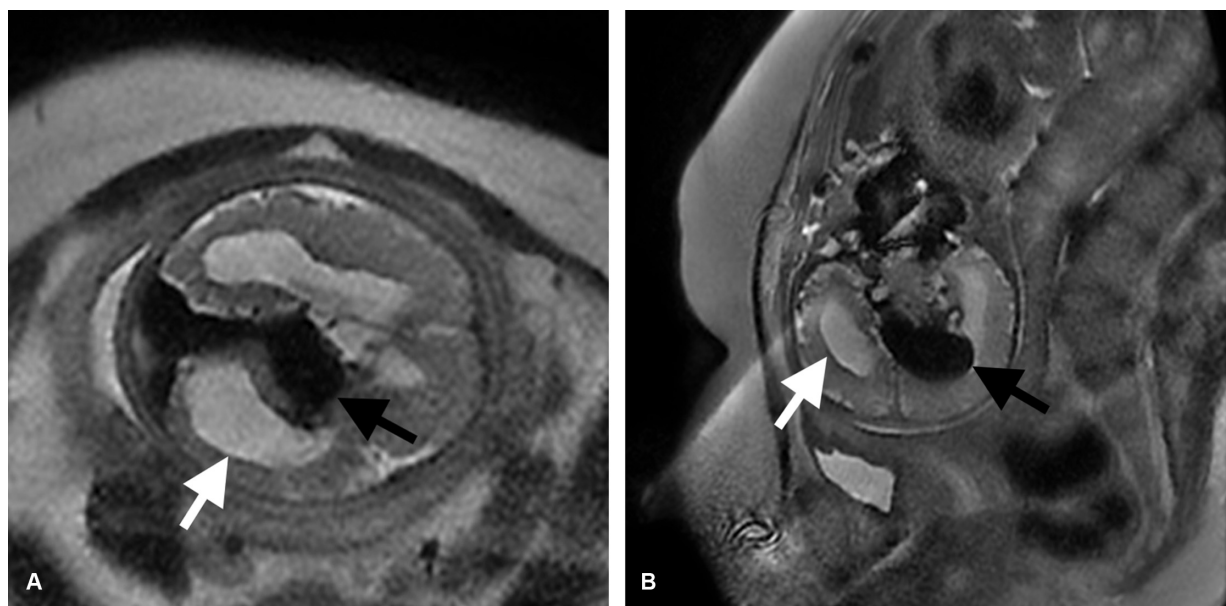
(a) Axial and (b) coronal intrauterine T2-weighted magnetic resonance imaging in apnea shows median flow void (black arrows) and lateral ventricles dilatation (white arrows) due to vein of Galen aneurysmal malformation.
